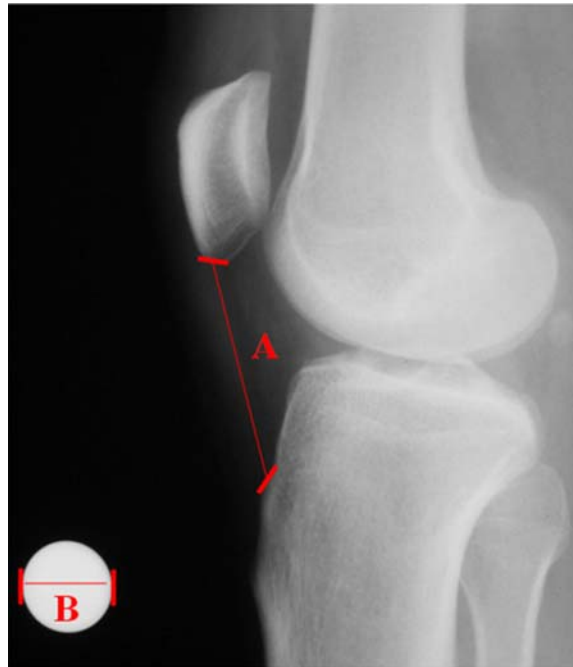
Lateral knee radiograph obtained with the knee extended weight bearing. The patellar tendon length is estimated by measuring the length of the "A" line between the inferior pole of the patella and the superior aspect of the tibial tubercle. Calibration marker length is from the "B" line
